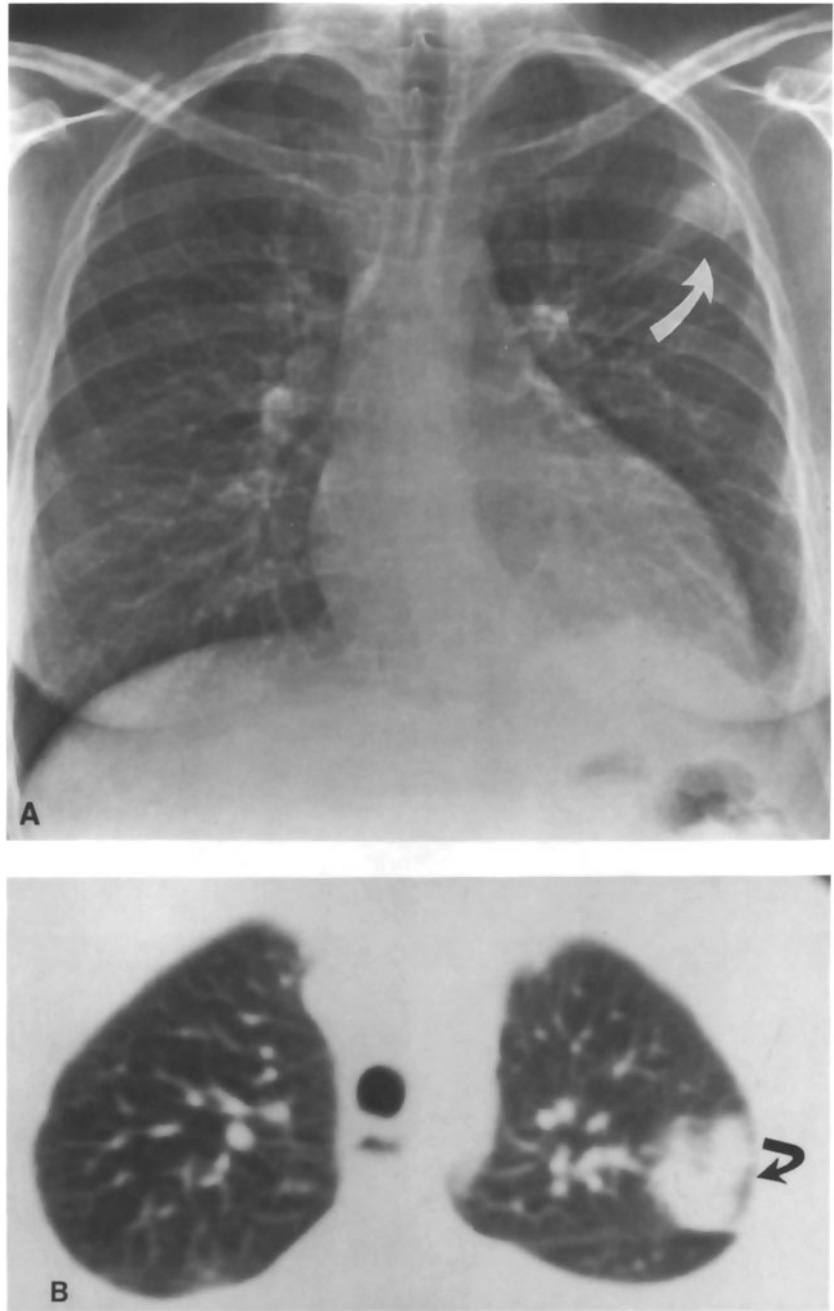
Pulmonary infarct. (A) A small opacity in the periphery of the left upper lobe of a diabetic with fever and a foot ulcer is due to a pulmonary infarct. The opacity is caused by a hemorrhagic infarct in a secondary pulmonary lobule. A straight interface along the bottom of the opacity is caused by a marginating interlobular septum. (B) A CT scan confirms the presence of the peripheral opacity. Other scan sections demonstrated additional bilateral infarcts and a left pleural effusion.
